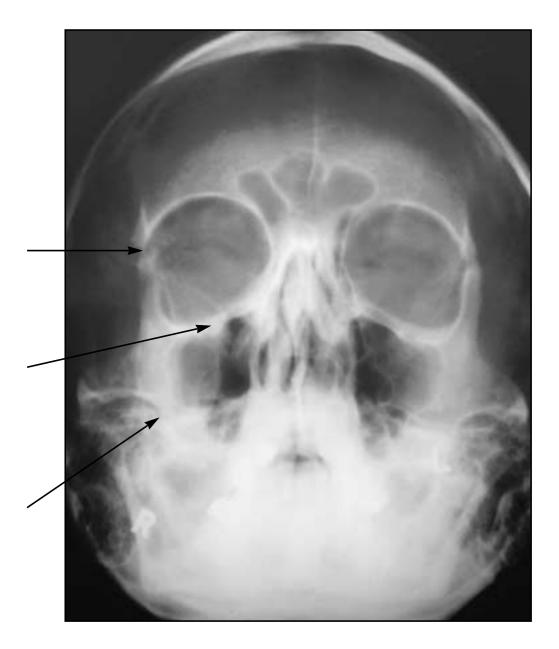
Occipito-mental radiograph of the head. The arrows indicate a fractured right molar (cheekbone).
